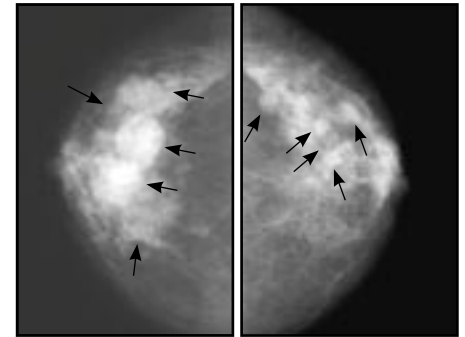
Craniocaudal films showing multiple round densities (indicated by arrows) within both breasts, suggestive of multiple cysts. An ultrasound would generally be performed to characterise these lesions and confirm that they are cystic in nature
